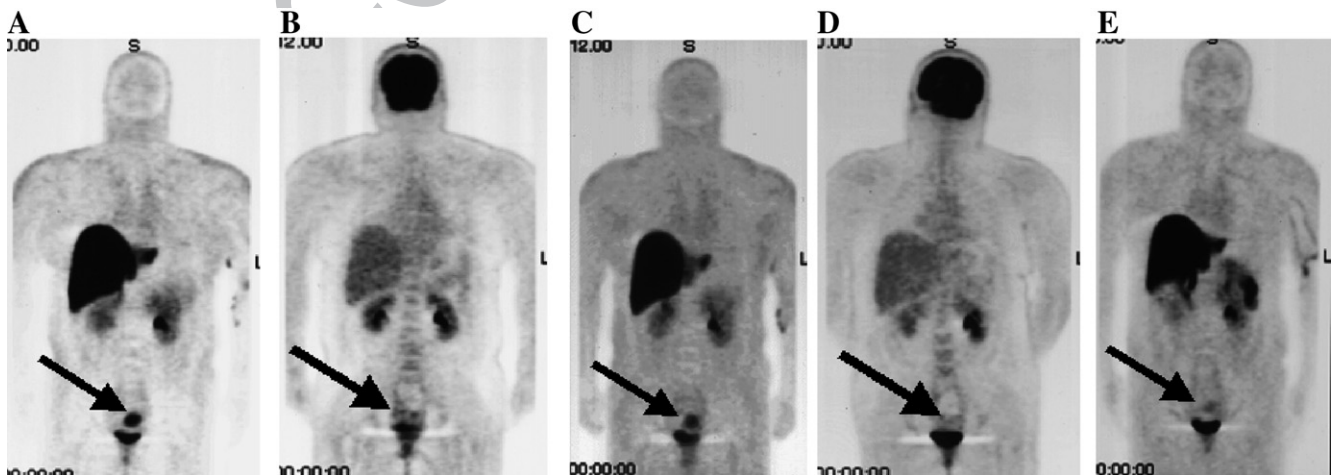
Endometrial PET during hormonal treatment. Before initiation of treatment: (A) FES-PET showed clearly increased uptake in the endometrium regions and (D) FDG-PET showed slightly increased uptake equivalent to liver uptake. Three months after initiation of treatment, FES-PET showed (B) remaining FES uptake in endometrium site, but (E) FDG-PET showed no abnormal finding. After additional treatment, (C) FES-PET showed no abnormal findings.
